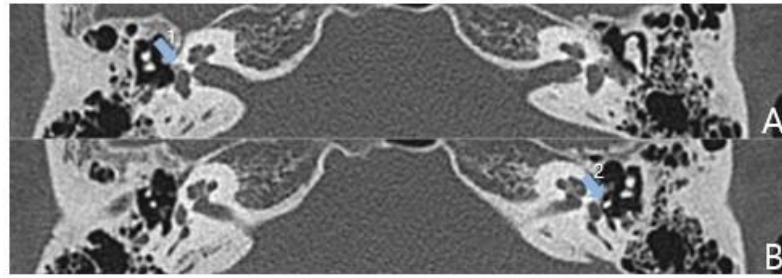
Preoperative(Rt) CT scan finding. (A) Preoperative CT scan showed lucent change of fissula ante fenestram(blue arrow 1) in Rt ear. (B) Previously inserted piston wire in Lt ear(blue arrow 2) was well in situ.
